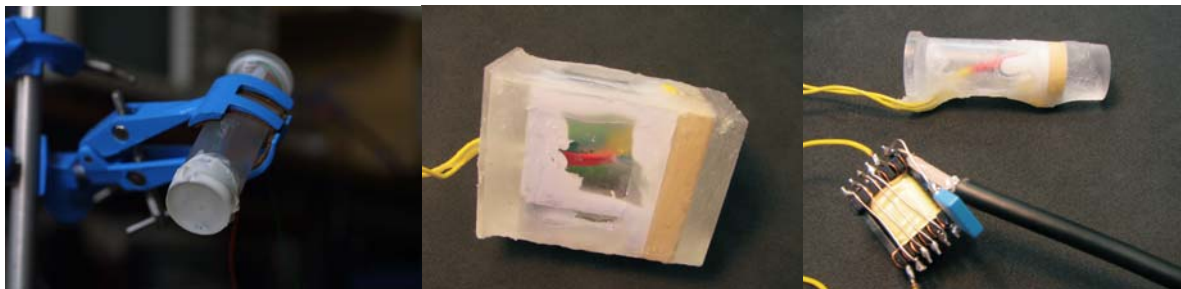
Three undamped ultrasound transducers with centre transmit frequencies between 200 kHz and 2.5 MHz.
